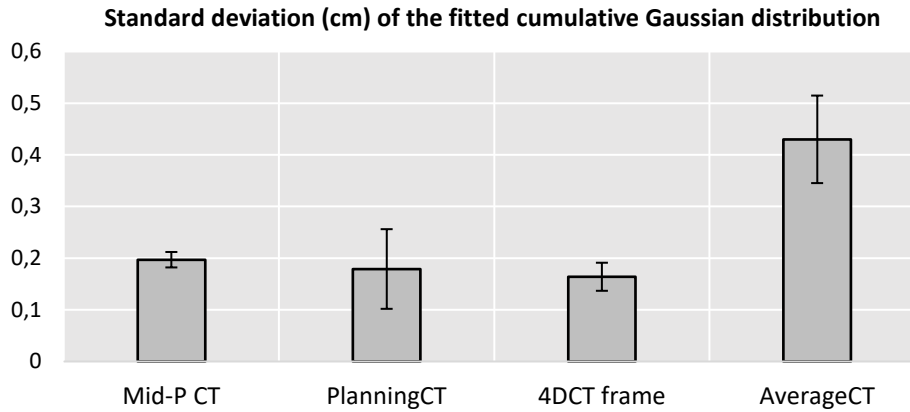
Mean and standard deviation of sigma values derived from the fitted cumulative Gaussian distribution along the lines drawn in the diaphragm-lung interface for five patients. The Mid-P CT has much higher image sharpness compared to the Average CT and just below that of the free-breathing planning CT and one 4DCT frame.
